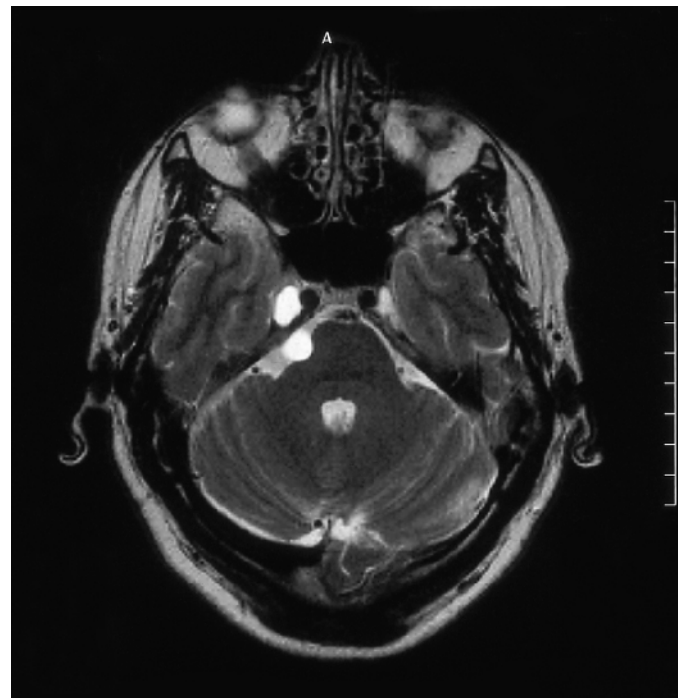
Growing arachnoid cyst after observation (MRI, T2, slice-thickness 5 mm).
